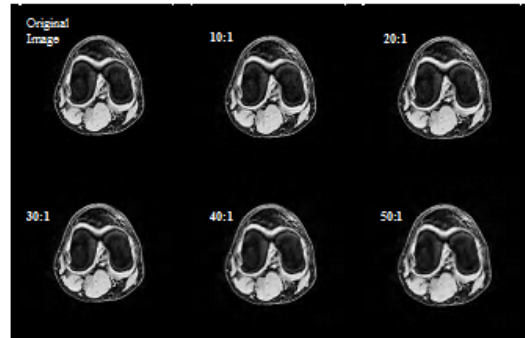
Comparison between original and compressed MRI Knee images
